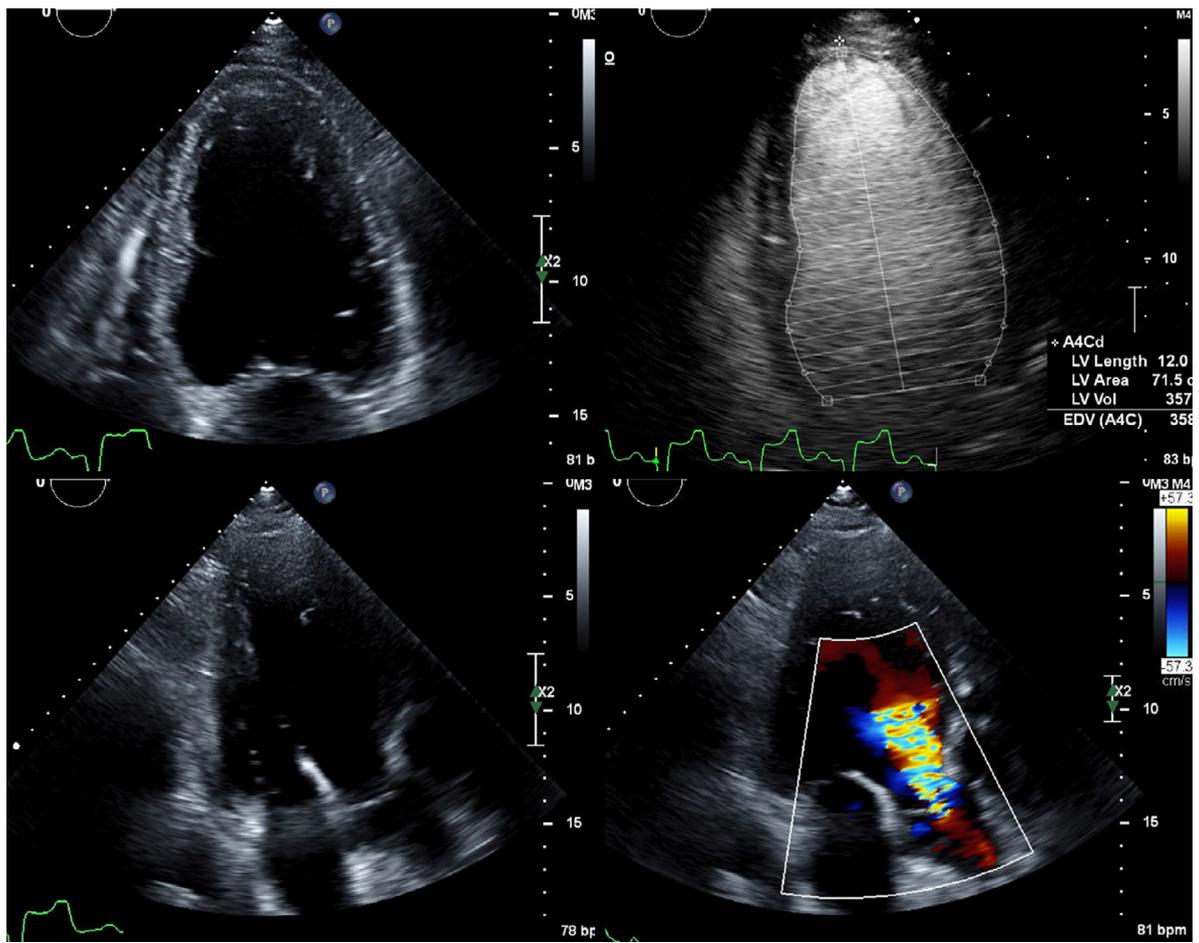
Top left*: Apical 4-chamber view showing severely dilated, elongated left ventricle (LV) with normal right ventricular (RV) size and systolic function. An ICD lead is seen in the RV (arrow). *Top right*: Apical 4-chamber end-diastolic frame with ultrasound contrast. LV end-diastolic volume was 358 ml with LVEF 19% by biplane Simpson's method. *Bottom left*: Apical long-axis view showing severely thickened, restricted anterior mitral leaflet (yellow arrow). The posterior leaflet (white arrow) was of normal thickness and motion. *Bottom right*: Apical long-axis view with color Doppler imaging showing severe aortic regurgitation (AR).
